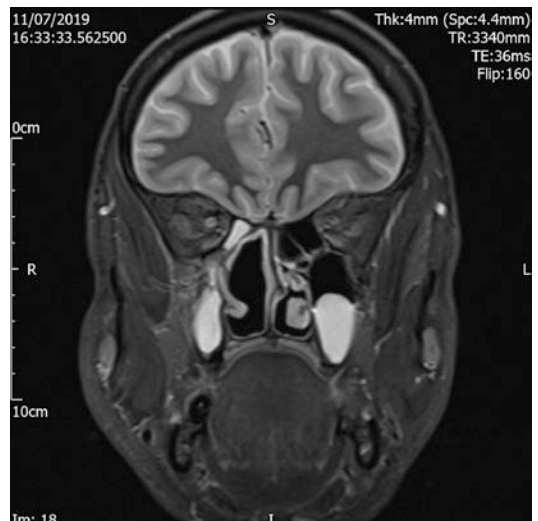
A 2 year post-treatment coronal T2-weighted MRI scan demonstrating complete resolution of the sino-nasal cancer with inflammatory changes in both maxillary sinuses and right ethmoids
